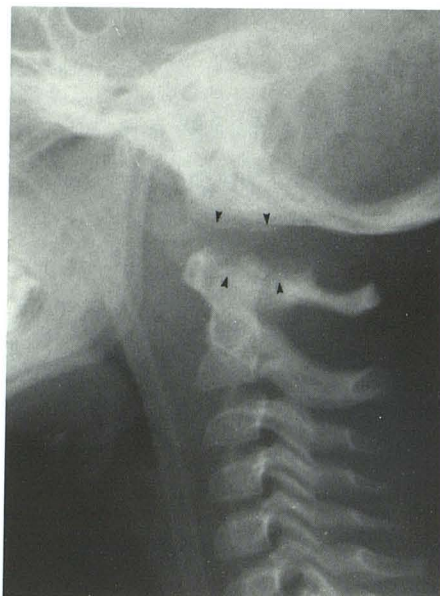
Case 1. Brow-up lateral cervical spine radiograph. Longitudinal distraction at atlanto-occipital junction and considerable prevertebral soft-tissue swelling. There is nearly 9 mm of vertical separation between occipital condyles and C1 articular facets (arrowheads) accompanied by mild anterior displacement of occiput on C1. An os odontoideum is present, and there is probably separation of posterior arches of C1 and C2.
